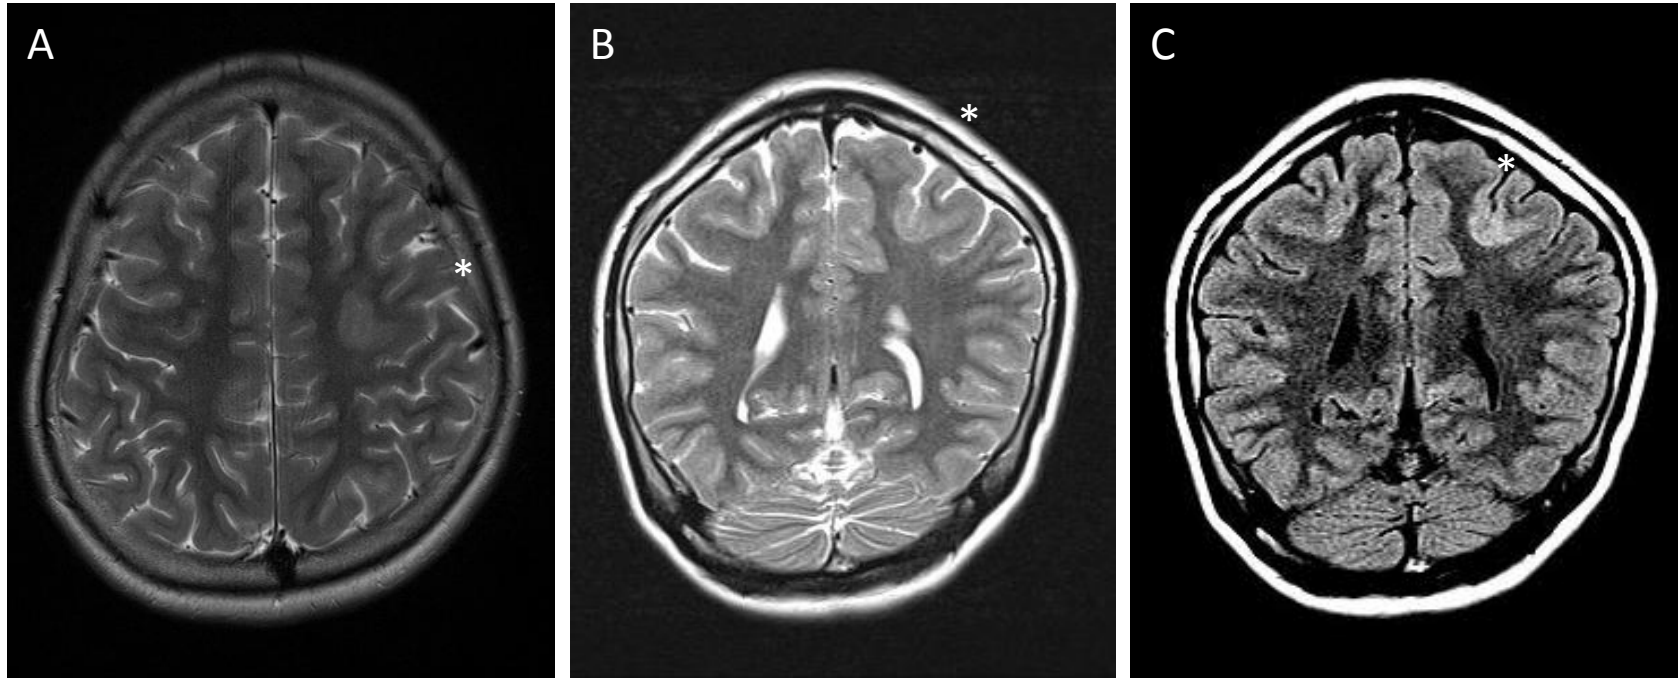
Gray matter type focal cortical dysplasia in an 18-year-old woman. (A) T2-weighted axial and (B) coronal images show an abnormal, thickened cortex with mild hyperintense signal changes in the left frontal lobe. (C) Coronal FLAIR image shows more prominent signal changes in the lesion.
